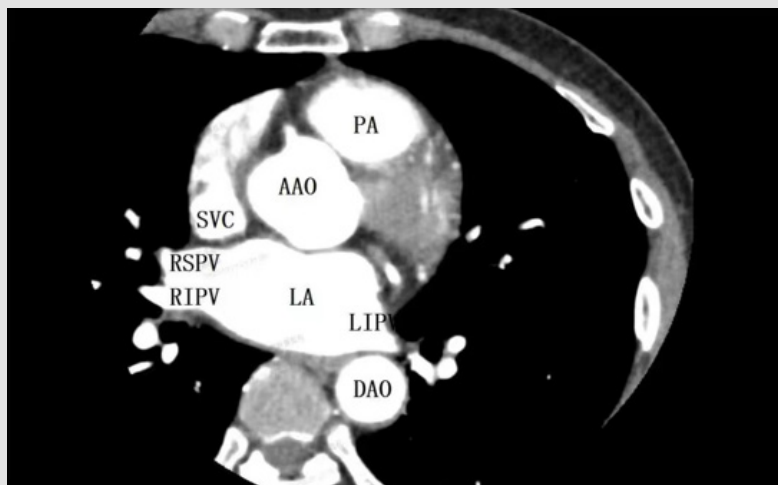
Complete left atrial CTA imaging.
